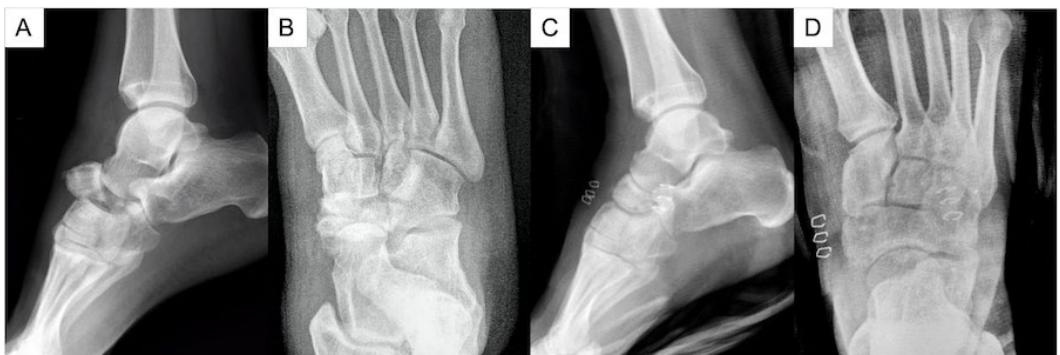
Preoperative lateral (A) and AP (B) view radiographs of a comminuted navicular fracture dislocation compared to postoperative lateral (C) and AP (D) view radiographs s/p navicular cerclage with UHMWPE suture tape in a right foot.
